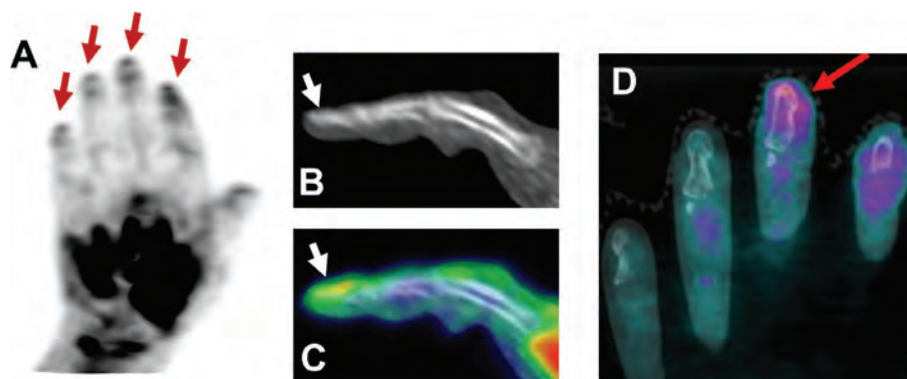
Nail matrix involvement in PsA: (A) Maximum-intensity projection through the PET scan of the left hand of a participant with PsA showing nail involvement; sagittal (B) CT and (C) PET/CT (PET in color, CT in grayscale) of the second digit showing nail bed inflammation. (D) shows nail bed involvement in a participant with PsA from our previous study for comparison.
